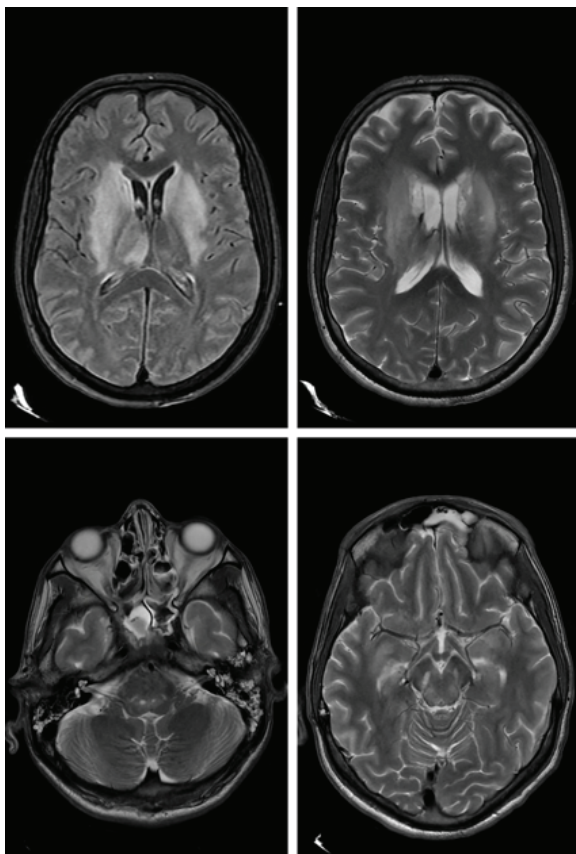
T2 and Flair brain MRI shows subcortical hyper intensities at the level of the thalamus, internal capsule, basal ganglia and brain stem (midbrain and pons)
